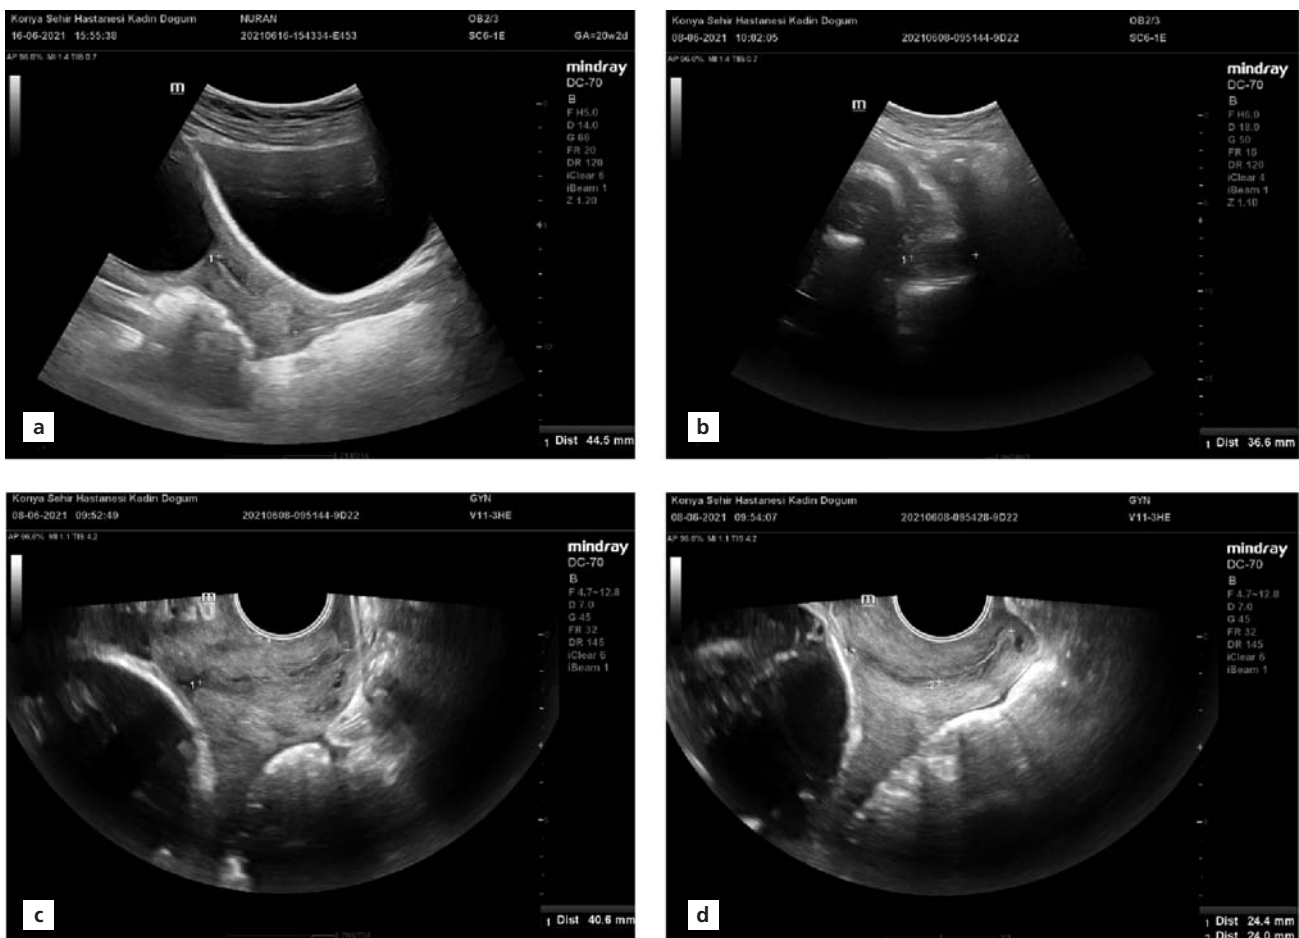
Sonographic images of cervical length measurements. (a) Transabdominal measurement with full bladder. (b) Transabdominal measurement with an empty bladder. (c) Transvaginal measurement. (d) Transvaginal two-line measurement.
